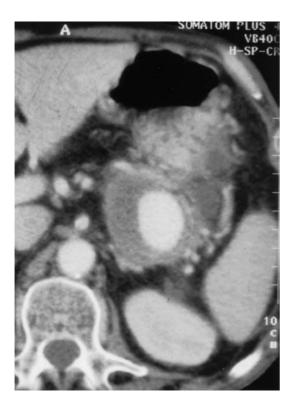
Pre-treatment CT scan demonstrates a 5.0-cm splenic artery pseudoaneurysm in the lesser sac
